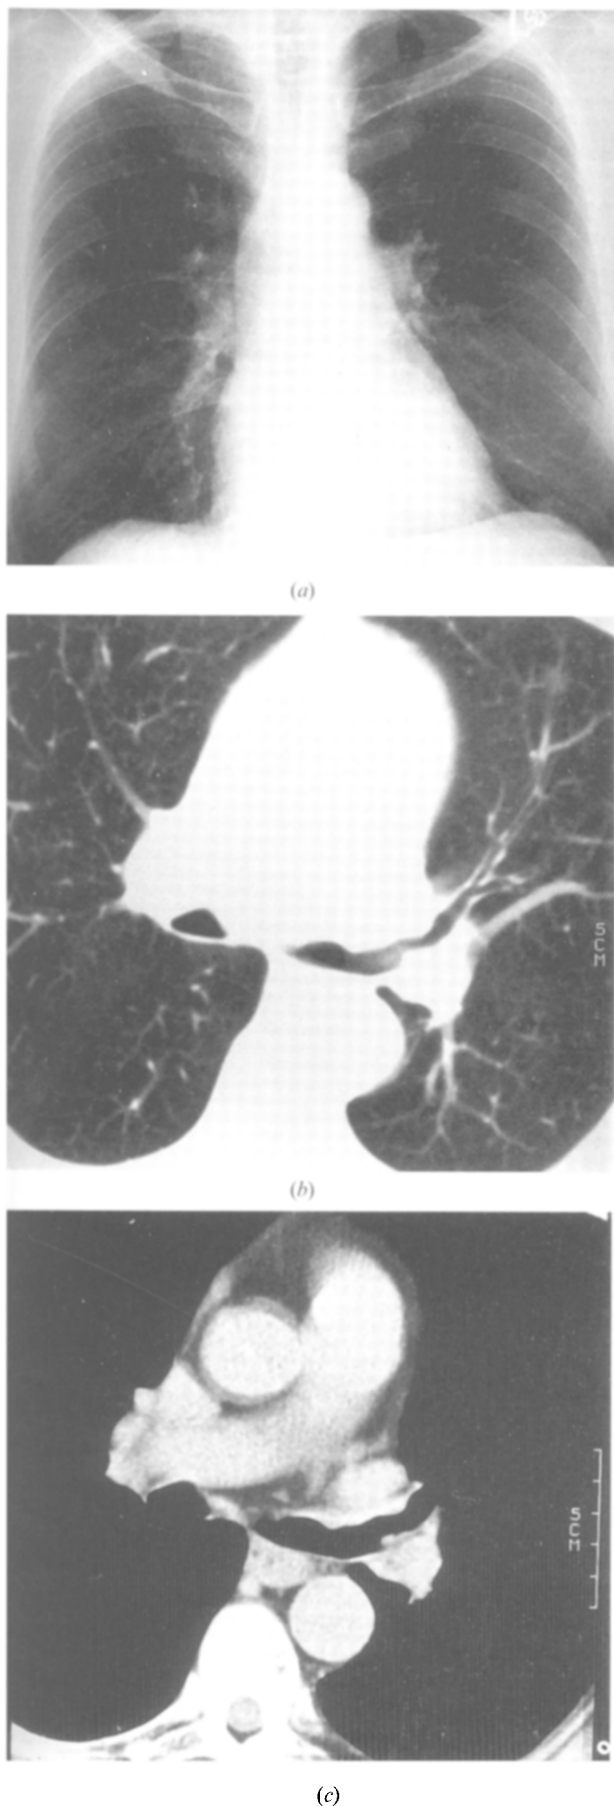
A 74-year-old male with a single episode of haemoptysis. (a) Normal chest radiograph. (b,c) CT (at lung and soft tissue settings) reveals irregular narrowing of the distal main and proximal left upper lobe bronchi suggestive of a carcinoma. These findings were confirmed at bronchoscopy.
